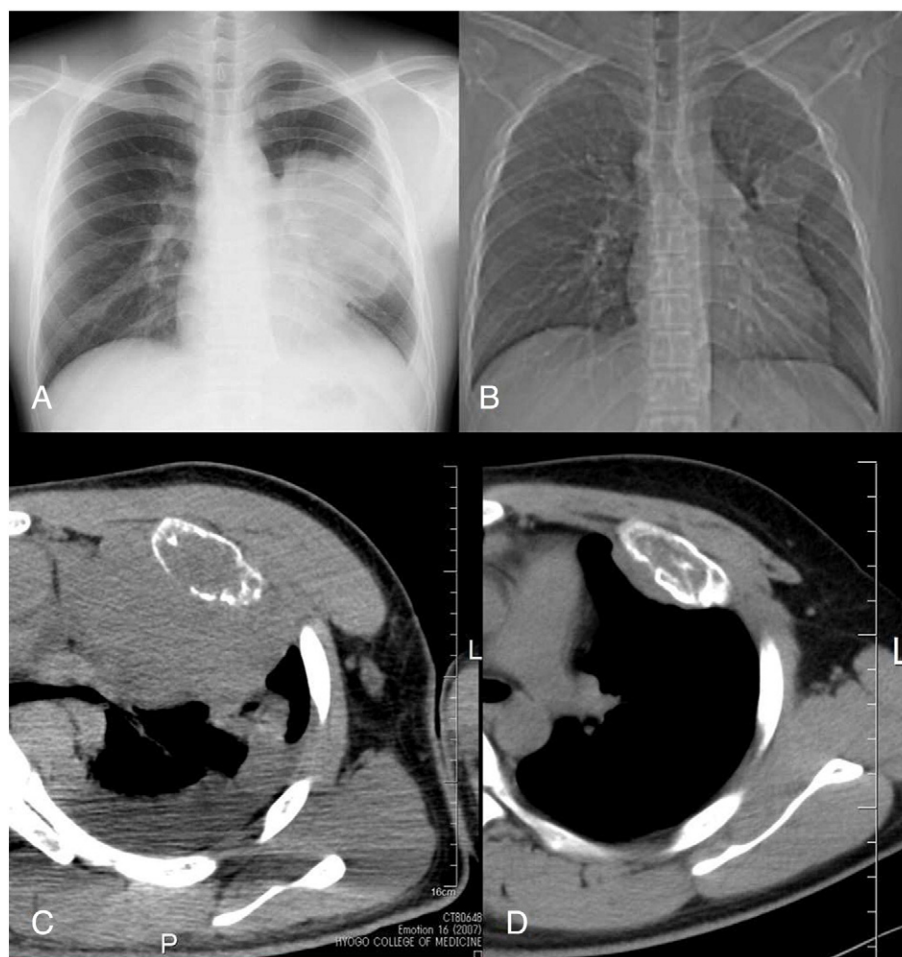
Radiological findings before and after chemotherapy. A (chest X-ray) and C (chest CT) show that a huge tumor with destruction of the left third rib is expanding to the left thorax at the first visit to our hospital. B (chest X-ray) and D (chest CT) demonstrate a markedly diminished tumor after chemotherapy.
